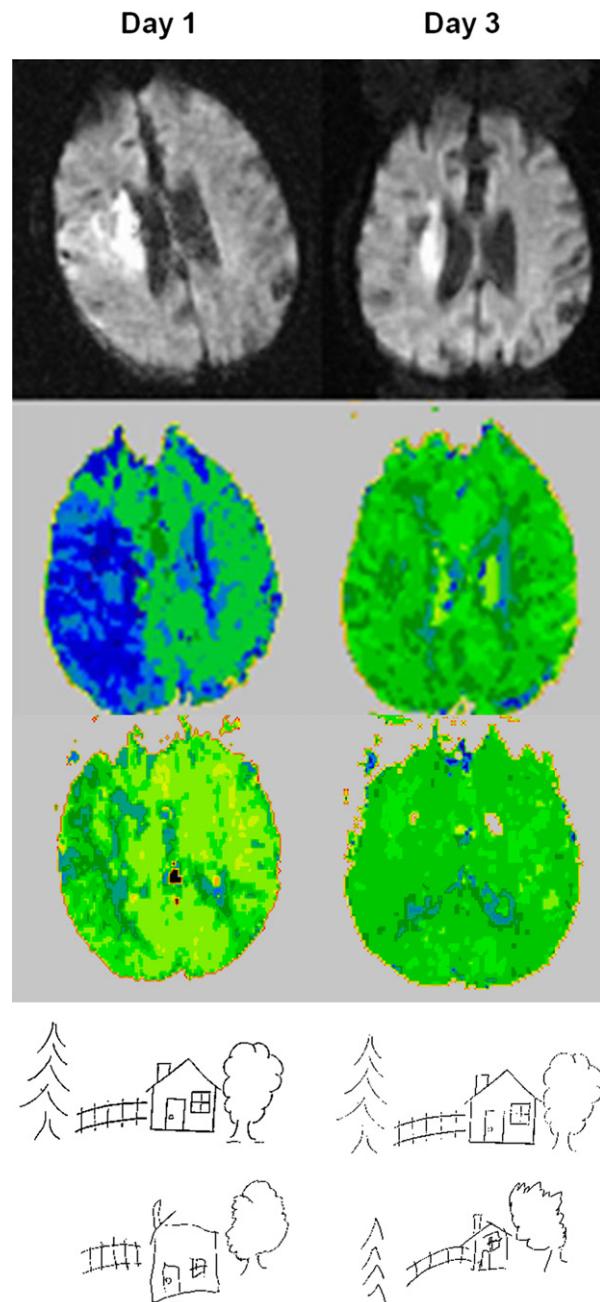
Top panel: DWI scans at Day 1 (left) and Day 3 (right) of Case 2. Middle 2 panels: PWI scans at Day 1 (left) and Day 3 (right) of Case 2. Lowest panel: Copy of the scene at Day 1 (left) and Day 3 (right) by Case 2.
